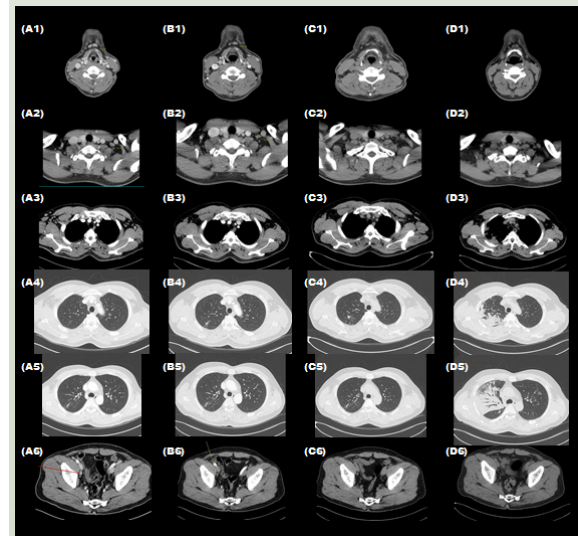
Neck CT, chest CT and Abdomen CT revealed a stage of Castleman's disease and chest CT revealed the reactivation for pulmonary Tuberculosis in chest CT. The first column images (A1-6) are first CTs to diagnose Castleman's disease in Aug 2016. Complete Response (CR) was confirmed after 14th Siltuximab in March 2019 (B1-6). Chest CT revealed that pulmonary Tuberculosis is suspected to re-activate in posterior segment of right upper lobe (C1-6). Pulmonary Tuberculosis aggravated and was combined pneumonia after 27th Siltuximab(D1-6)
